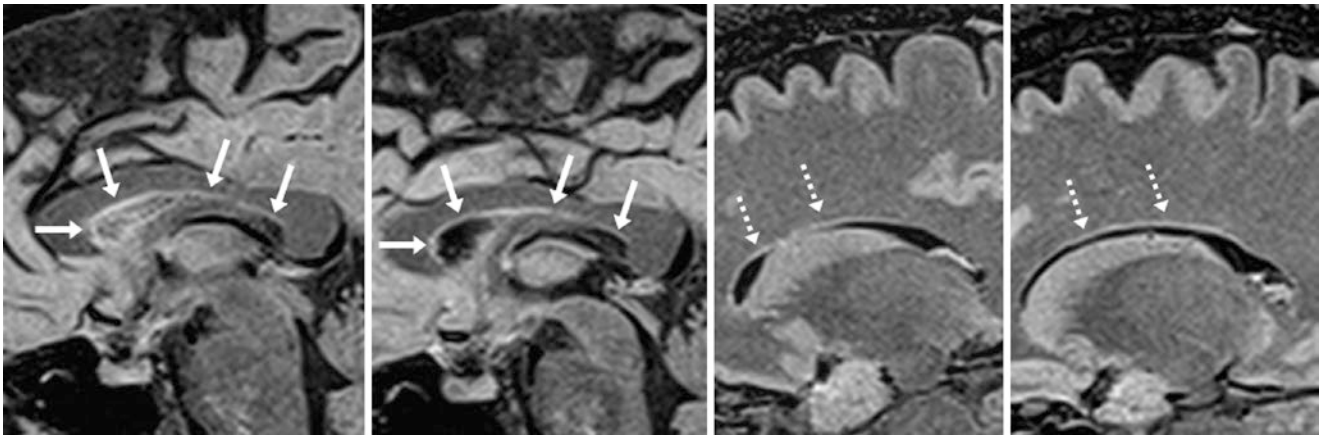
A 33 year old with normal, mild, linear hyperintense signal (arrows) in a parallel, nonirregular orientation relative to the lateral ventricles on midline 3T sagittal FLAIR images (left two images) at the callosal-septal interface. More laterally, at the subcallosal interfaces on
